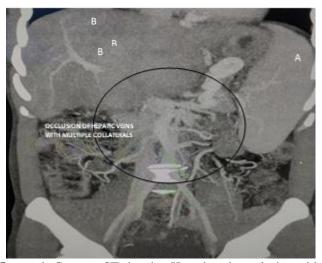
Contrast CT showing Hepatic vein occlusion with Hepatomegaly (B) and massive splenomegaly (A)
